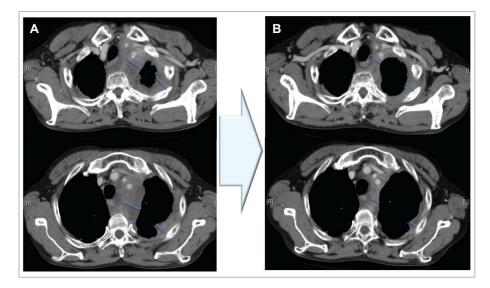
Computed tomography shows S-1+CBDCA treatment course.
